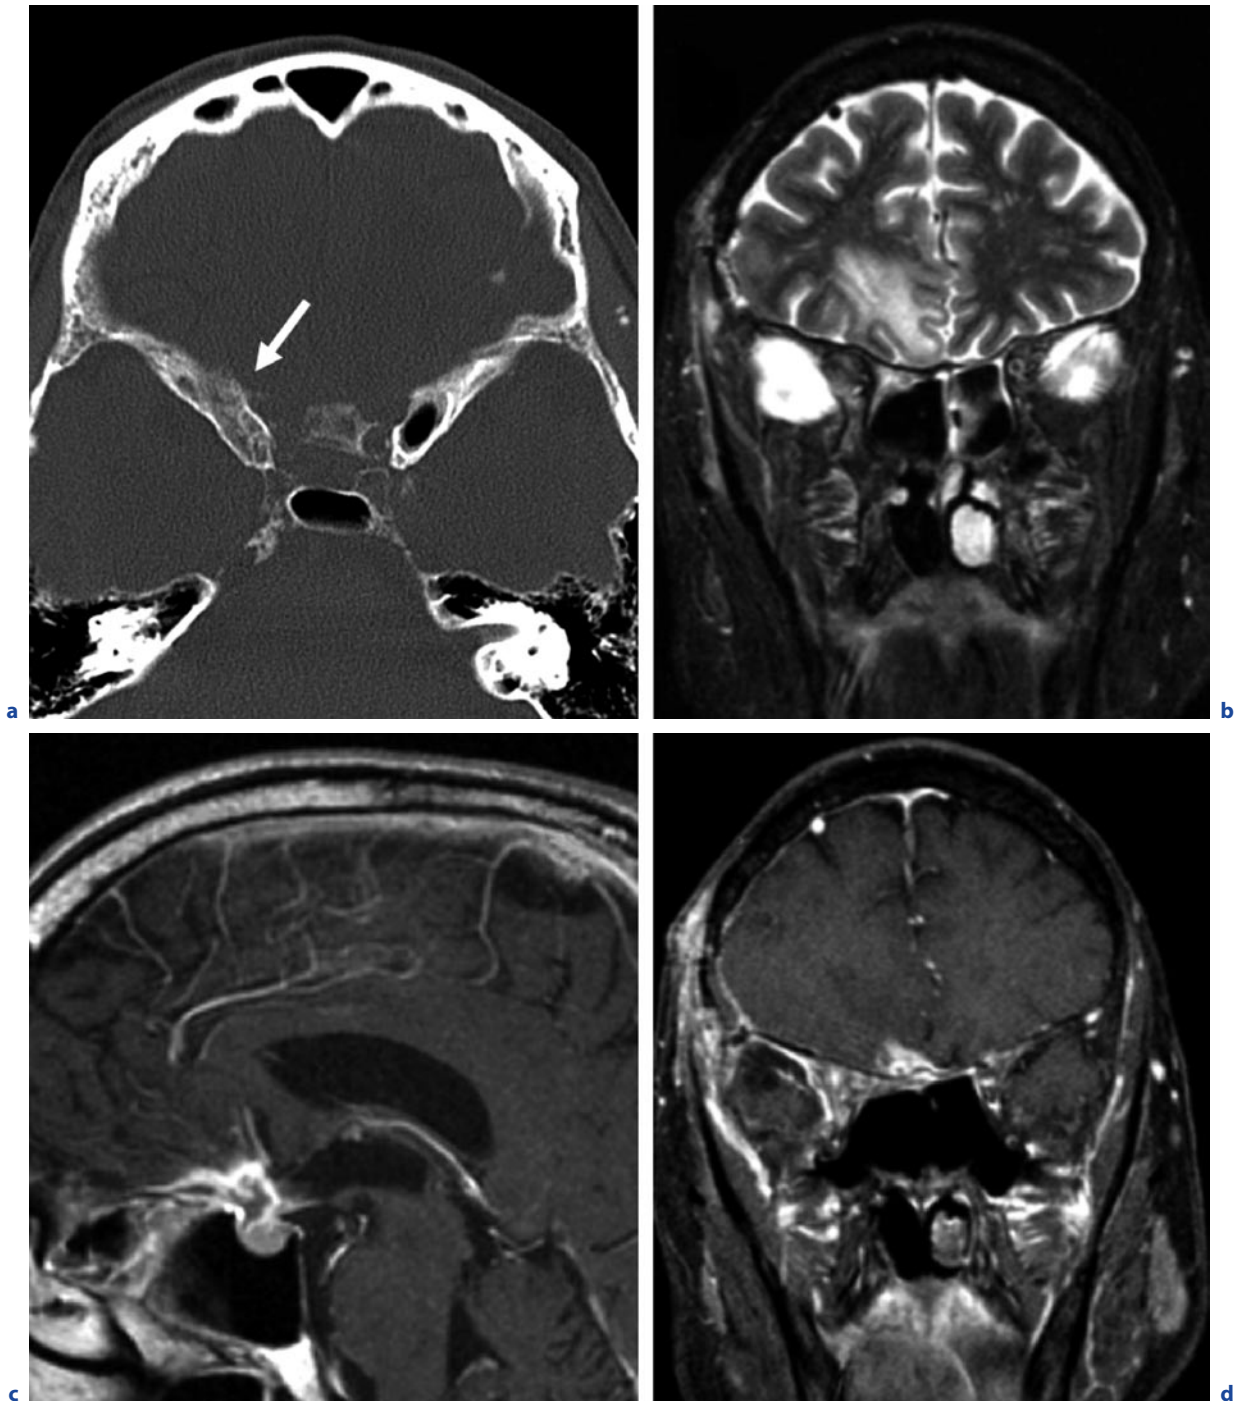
Invasive aspergillosis. a Axial computed tomogram. b Coronal T2-weighted image. c Sagittal T1-weighted image after contrast administration. d Coronal T1-weighted image after contrast administration. Signs of bone erosion on
